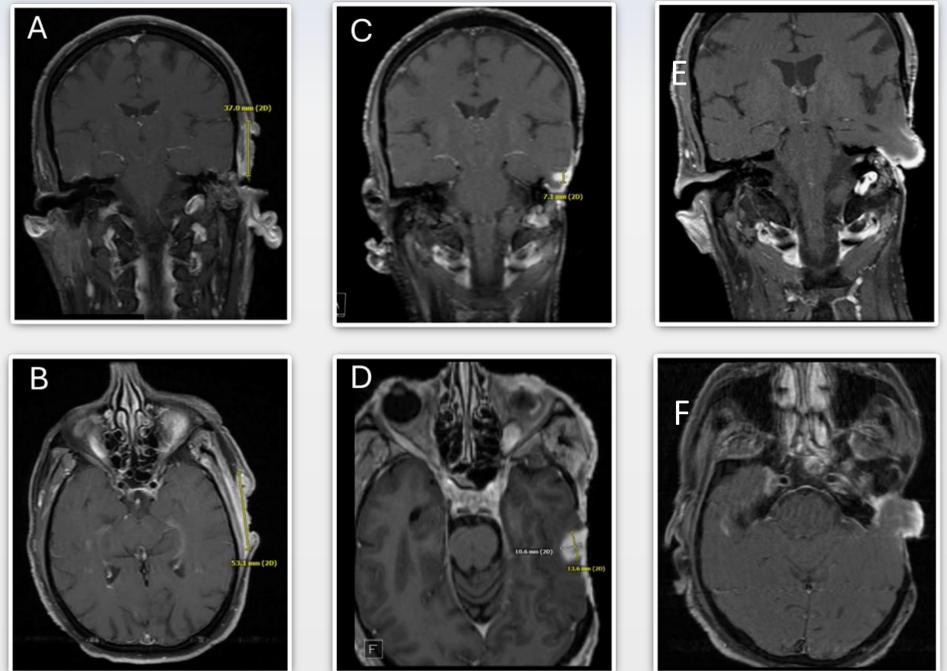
(A, B) T1-weighted post-contrast MRI demonstrating an enhancing lesion of the left pinna and temporal scalp at initial presentation (C, D) Two-year post-treatment scan demonstrating dural and cortical enhancement. (E, F) Herniation of gliotic temporal lobe through the resection defect, consistent with temporal encephalocele.
